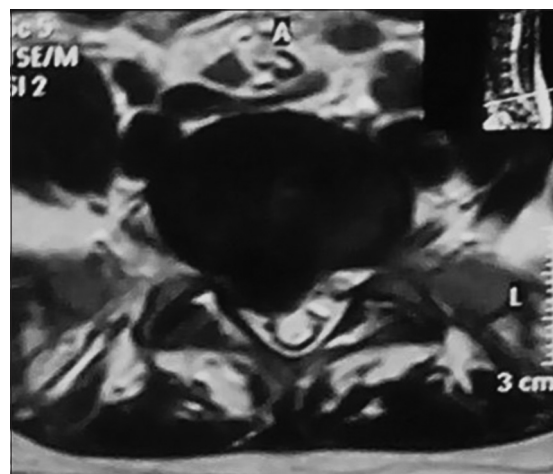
Pre-operative magnetic resonance imaging lumbosacral spine (axial T2W images with L5-S1 right disc herniation)
